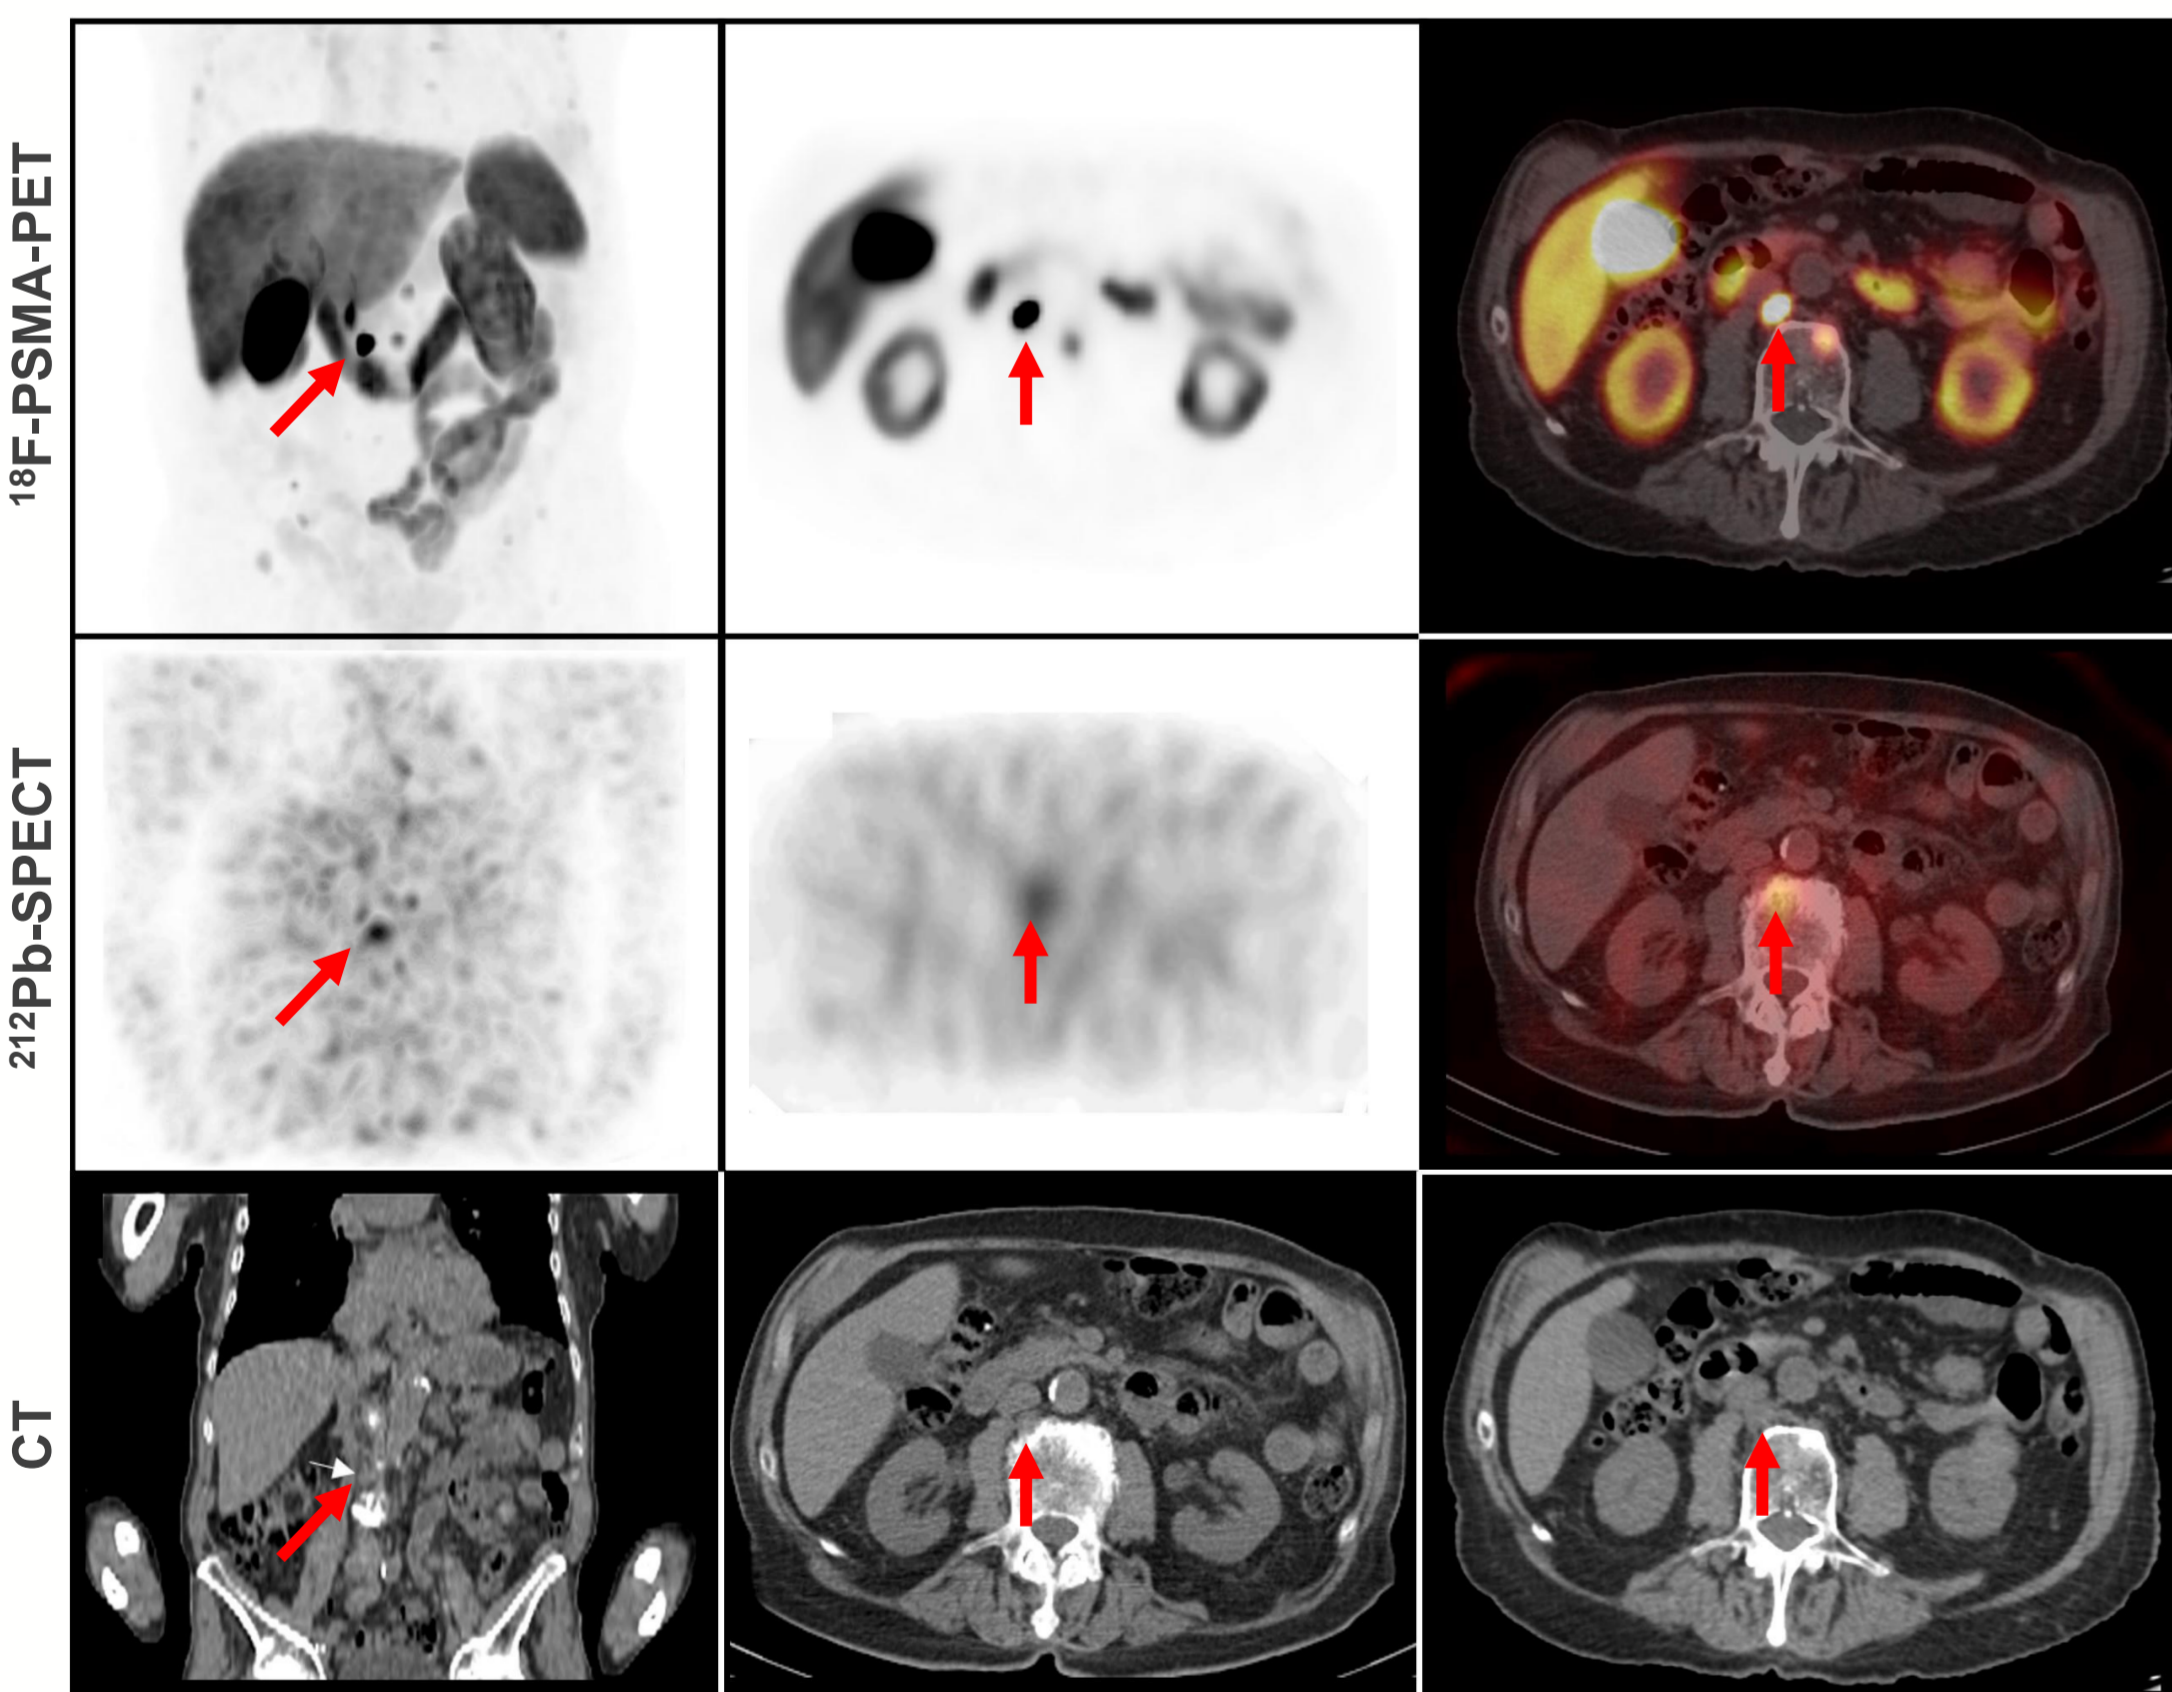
Retrocausal lymph node tumor metastasis (red arrows) demonstrated in patient ID03 with SUVmax 77 from 18F-PSMA-PET (a,b,c) and measuring 11x14x16mm on CT (g,h,i). AB001 uptake demonstrated on ²¹²Pb SPECT imaging at 4 hours post-administration (d,e,f).
